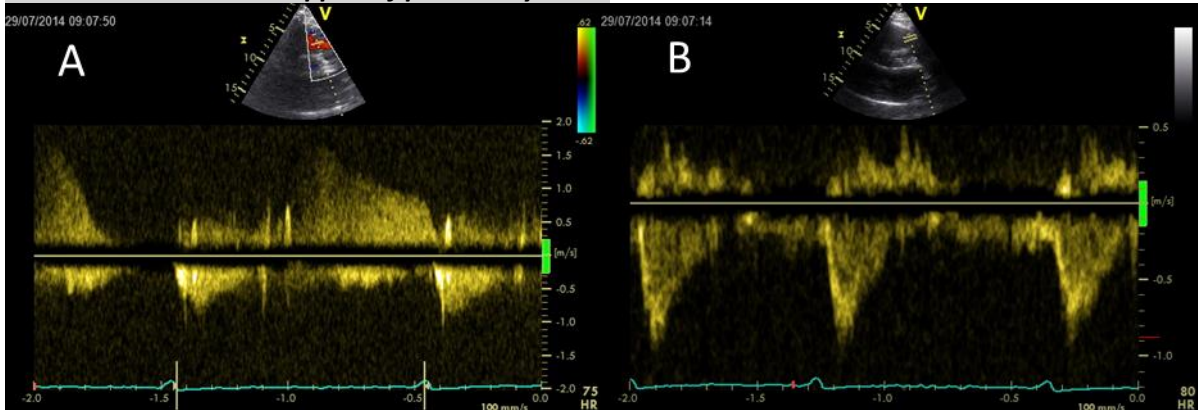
CW Doppler of pulmonary valve regurgitation (A) and PW Doppler of pulmonary valve (B)
